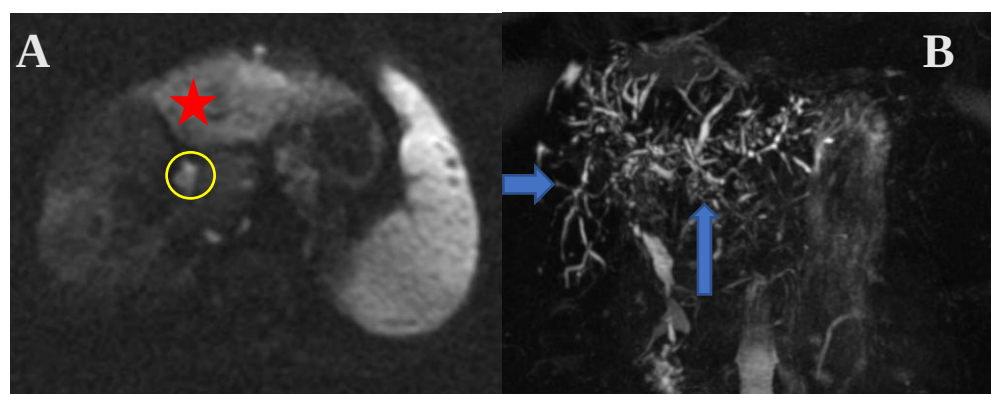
& 4B: A sixty-five-year-old female, presented with jaundice, Axial DWI at the level of the liver shows ill defined areas of restricted diffusion (star) involving the sub capsular surface of both lobes of the liver. Few lymphnodes showing restricted diffusion (circle) is seen the porta hepatis. Reformatted 3D-MRCP shows multifocal dilatation of the intrahepatic biliary radicles with intervening segments of narrowing, giving a beaded appearance (block arrows) suggesting sclerosing cholangitis.
